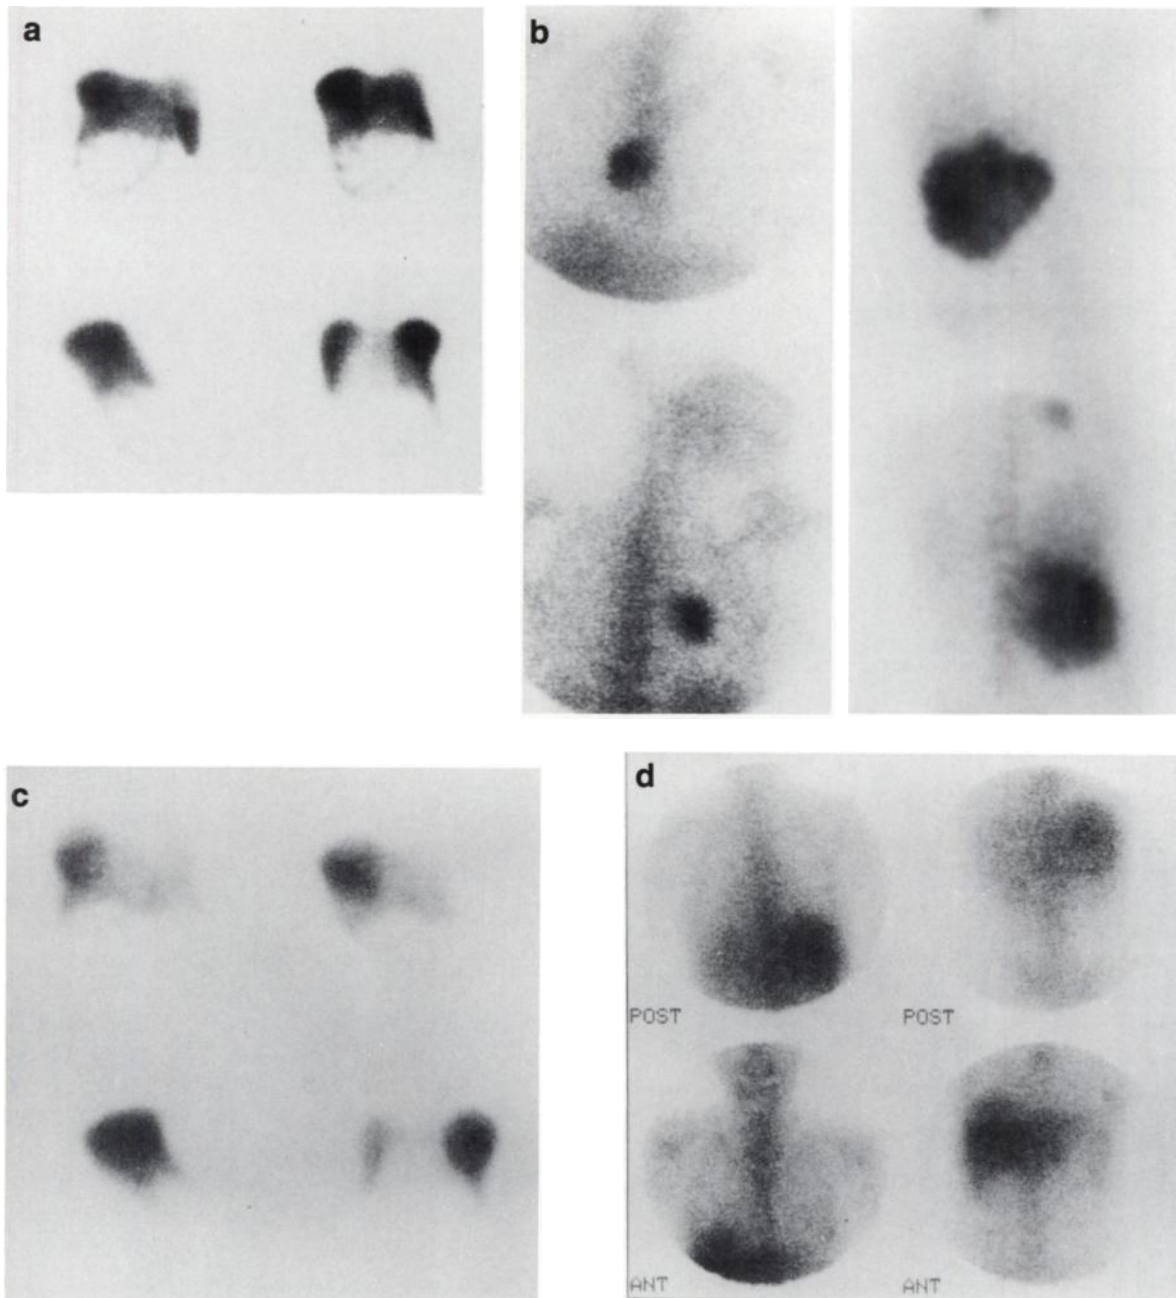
A 41-yr-old female with NHL with liver and mediastinal involvement. (a) Liver-spleen scintigraphy shows hepatomegaly with a large photopenic defect in the inferior aspect of the right liver lobe. (b) Anterior (top) and posterior (bottom) ^{67}Ga images of the mediastinum (left) and the abdomen (right) show abnormal increased activity in the inferior aspect of the right lobe of the liver and abnormal activity in the right mediastinum. (c) Liver-spleen scintigraphy after three chemotherapeutic courses shows a decrease in liver size and in the size of the photopenic abnormality and (d) ^{67}Ga scintigraphy is normal. The patient achieved complete response and has been free of disease for 6 yr after completing chemotherapy.
